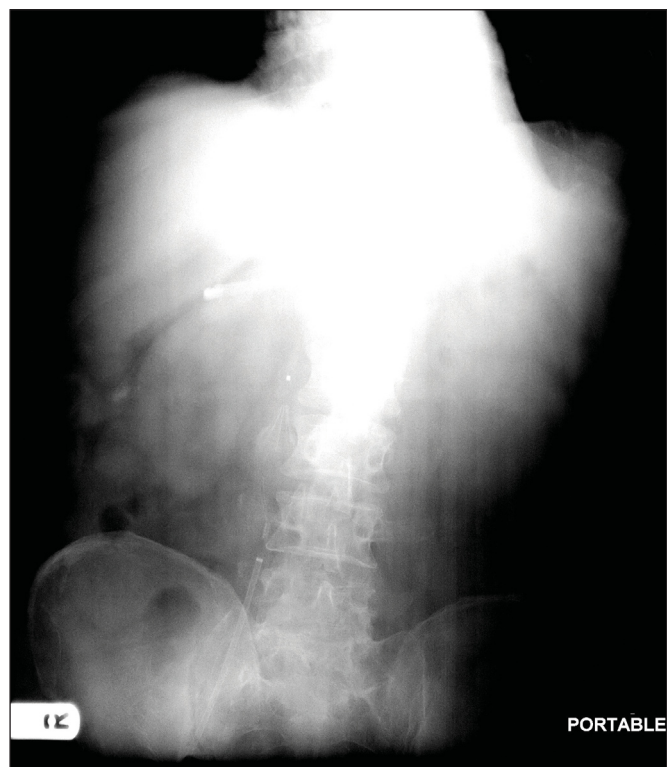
Mobile X-ray of the abdomen showing the filter tip at the level of the first lumbar vertebra near to the midline.
